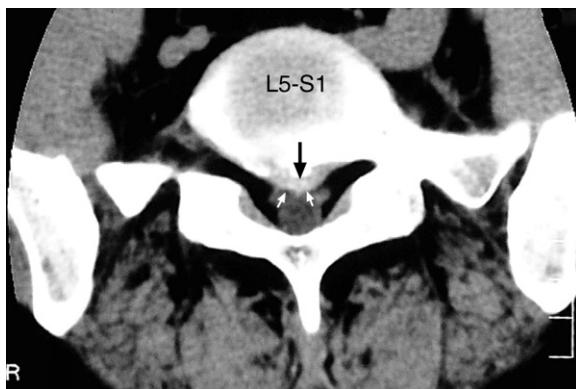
Lumbar spine CT axial image at the L5–S1 level. Note: (1) the median disc protrusion (black arrow) abutting the left, and particularly the right, nerve roots (small white arrows) and indenting the dural tube anteriorly. R = right side of patient.
